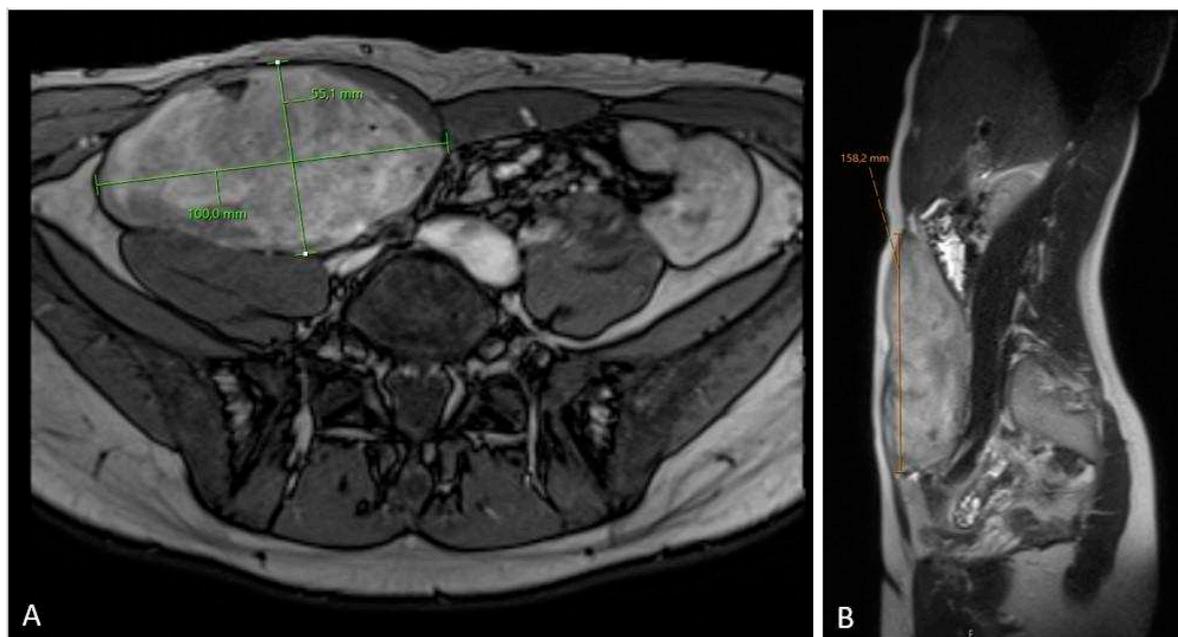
The 3-months MRI controll scan (A – axial plane; B – sagittal plane) after initial diagnosis showing stable tumor size.
